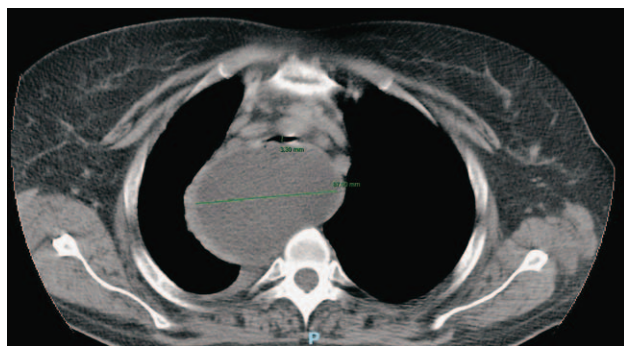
CT FINDING AT THE TIME OF ADMISSION
